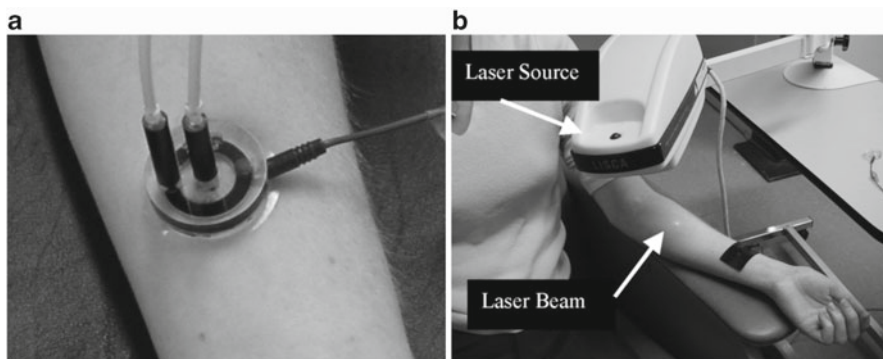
a Measurements of direct and indirect effect of vasoactive substance using single-point laser probes: one probe is used in direct contact with the iontophoresis solution chamber (*colored ring*) and measures the direct response. The center probe measures the indirect response (nerve axon-related effect). A small quantity (<1 mL) of 1 % acetylcholine chloride solution or 1 % sodium nitroprusside solution is placed in the iontophoresis. A constant current of 200 mA is applied for 60 s achieving a dose of 6 mC/cm^{-2} between the iontophoresis chamber and a second non-active electrode placed 10–15 cm proximal to the chamber (black strap around the wrist). This current causes a movement of solution to be iontophoresed toward the skin. b Laser Doppler flowmetry: A helium-neon laser beam is emitted from the laser source to sequentially scan the circular hyperemic area (seen surrounding the laser beam) produced by the iontophoresed vasoactive substance to a small area on the volar surface of the forearm
